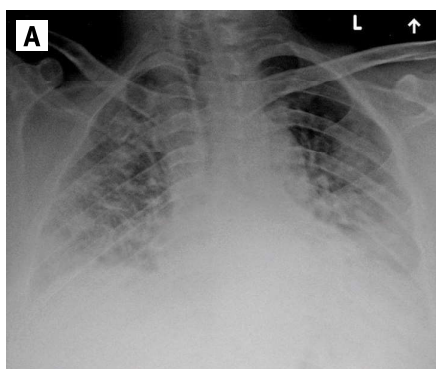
A 59-year-old man with a 6-day history of fever, fatigue, cough, and shortness of breath. Frontal chest radiograph [A] obtained 6 days after symptoms onset shows lower lobe predominant bilateral consolidation which obscures the left hemidiaphragm. There are no pleural effusions. Unenhanced chest CT [B,C] performed one day later [B] shows peripheral ground-glass opacities, some distributed in a nodular fashion (curved arrow [C] coned down view at the level of the takeoff of the right upper lobe bronchus, demonstrates the 'crazy paving pattern', thickened intralobular septa superimposed on ground glass opacities (straight arrows)
